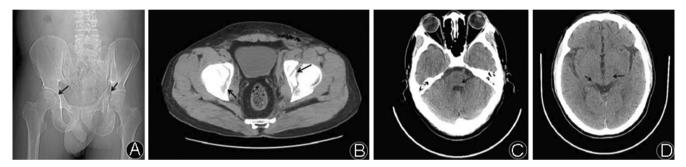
A: Pelvic X-ray film showing bilateral acetabular fractures when the patient left the hospital. B: Axial CT scan of the hip showing bilateral acetabular fractures when the patient left the hospital. C, D: Axial CT scan of the head showing no infarction when the patient was discharged.
